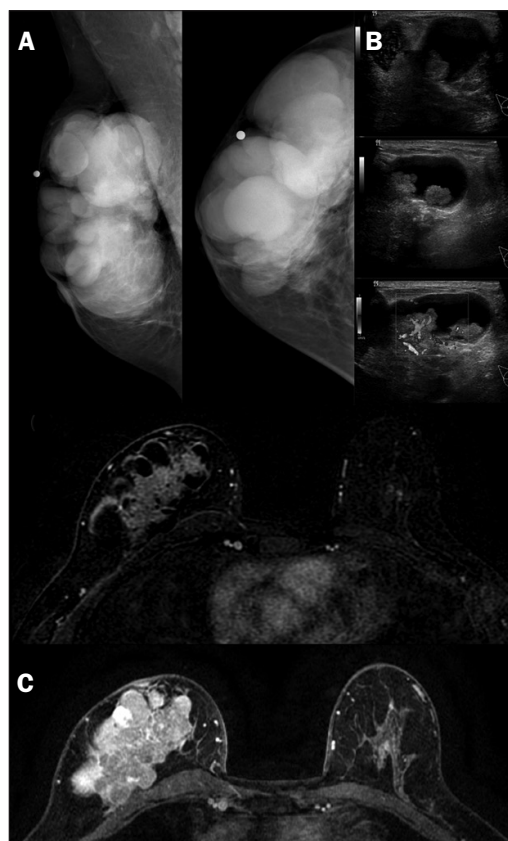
Radiologic findings. (A) Mammography: multiple round image in the whole right breast; (B) breast ultrasound: cystic mass with intense vascular flow; (C) MRI findings: infiltrative solid mass with intense early enhancement and washout kinetic curve associated with multiple cysts occupying the right breast.
